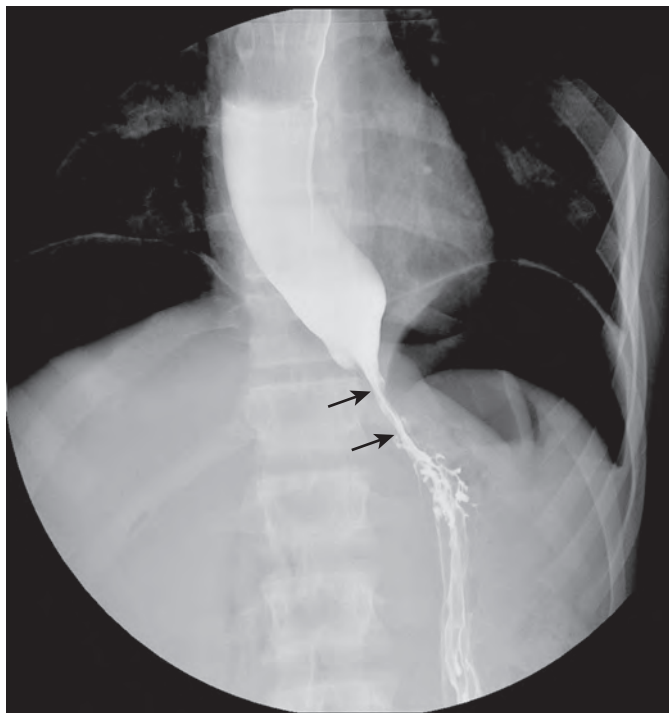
Postoperative wrap edema. One day after laparoscopic fundoplication wrap surgery, the patient had chest pain and difficulty handling her secretions. A low-magnification radiograph shows a large volume of gas (carbon dioxide) underneath the left and right hemidiaphragms. The esophagus just proximal to the fundoplication is a tight 3 mm in luminal diameter (arrows). The thoracic esophagus is dilated and showed delayed esophageal emptying. One week later, the esophageal obstruction caused by edema of the fundoplication wrap had resolved. The esophageal narrowing increased to about 8 mm.
